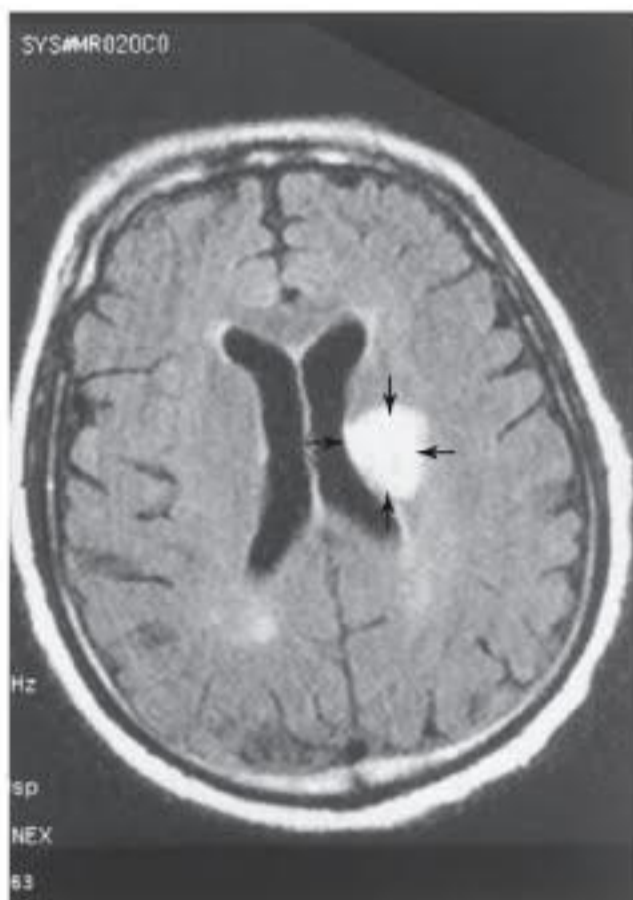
Computed tomography scan of the brain without contrast demonstrates a large, acute left thalamic hemorrhage. The acute bleeding in the thalamus on the left is white on the scan and is indicated with arrows.
